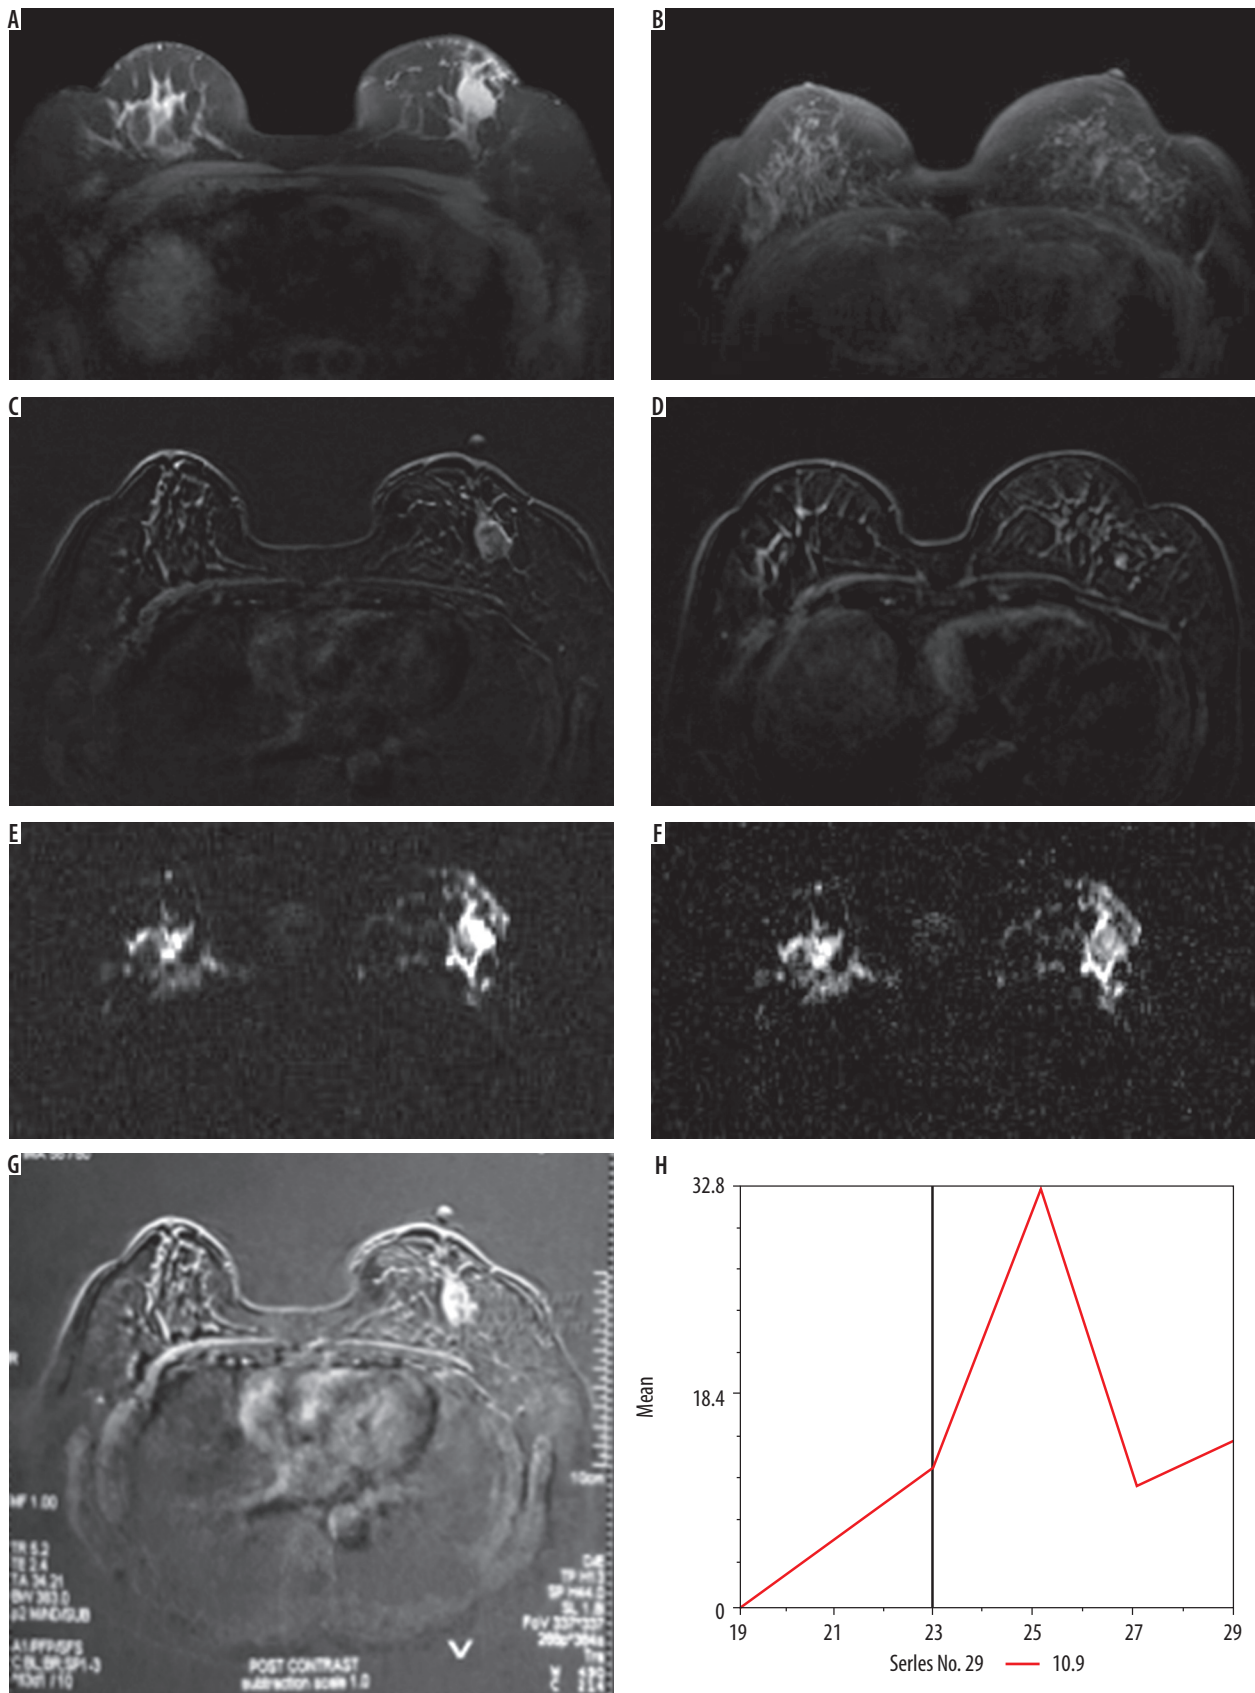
Magnetic resonance breast imaging in a case of invasive ductal carcinoma in a 46-year-old woman. A) Fat sat axial T1WI showing a well-defined oval, irregular mass lesion with speculated margins seen in the left breast. B) Maximum intensity projection image showing rim enhancement of the lesion. C) Fat sat axial T1W post contrast image showing rim enhancement of the mass lesion. D) Fat sat axial T1W post contrast image showing a small enhancing non-mass area adjacent to the mass, which was not detected on mammogram, tomosynthesis, or in ultrasound of the breast. E) Axial diffusion-weighted imaging showing hyperintense signals in the mass with F) corresponding low apparent diffusion coefficient value (restriction on diffusion weighted imaging). G-H) Time signal intensity curve of the mass showed type III kinetic curve (early washout)
